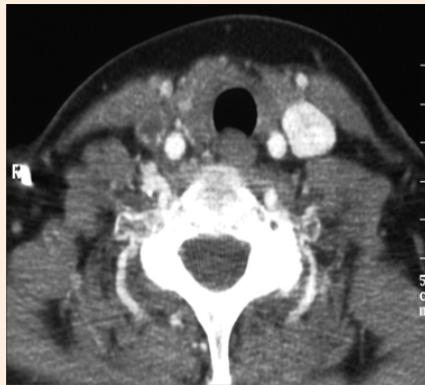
CT scan confirmation of right IJV thrombosis (arrow).
